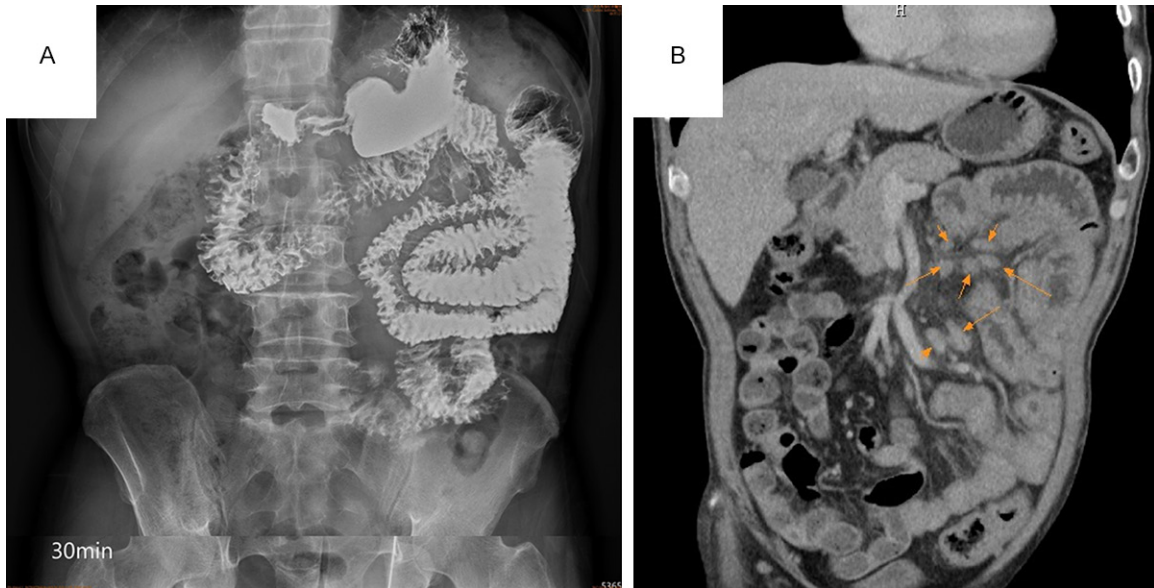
A. The small bowel barium series X-ray image showed segmental mucosal thickening of jejunum with a fixed position over the left upper abdomen. No obstructive or filling defect is seen. B. Abdominal CT image revealed multiple enlarged mesenteric lymph nodes (orange arrows).
